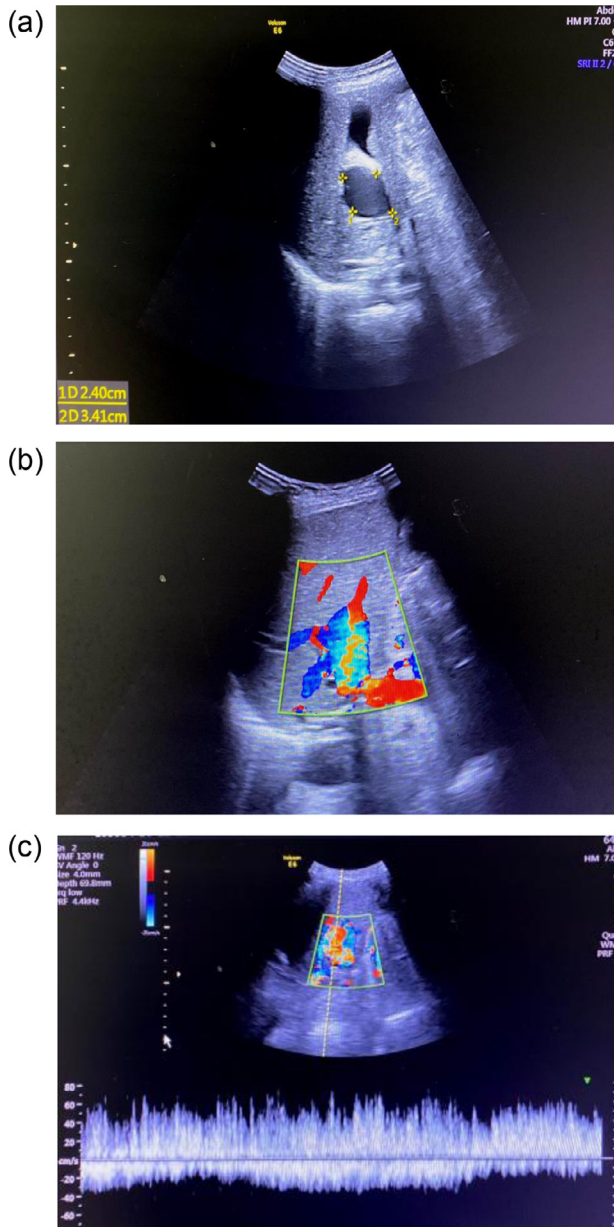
(a) Case 2- Ultrasound abdomen, depicting a focal anechoic intrahepatic cystic mass. (b) Case 2- Blood flow within the cystic mass and its branches. (c) Case 2- Monophasic venous waveform of PVA.
